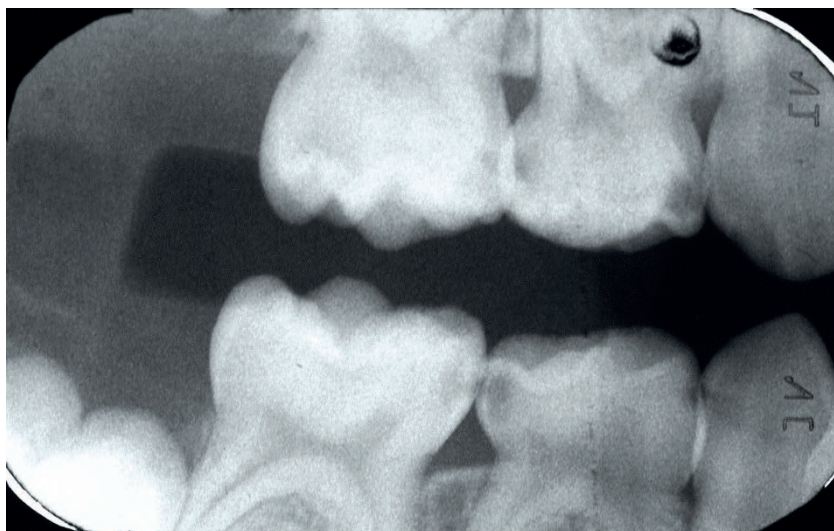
Radiograph of a 5-year-old child showing tooth 85 (lower right 2nd primary molar) with a mesial carious lesion and tooth 84 (lower right 1st primary molar) with a distal carious lesion extending into dentine. The dentinal lesion is likely to be cavitated and needs to be managed. A 'clear band of dentine' is visible between the advancing edge of the lesion and the dental pulp and fitting a crown at this stage has a high chance of success
